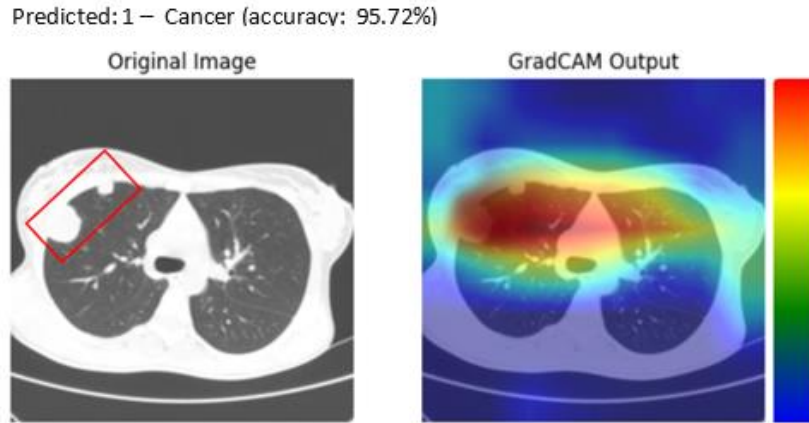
GradCAM result of CT image with a model of InceptionV3
